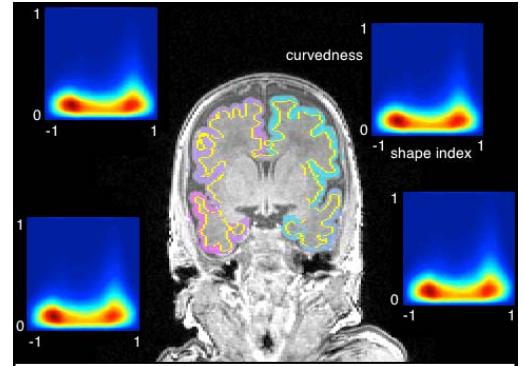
Compound image for a single subject T1-weighted MR. Grey/white matter boundary shown in yellow and grey-matter lobular segmentation shown in pastel. Associated with each lobe is a 2D histogram of shape index vs curviness, the two peaks correspond to gyral
